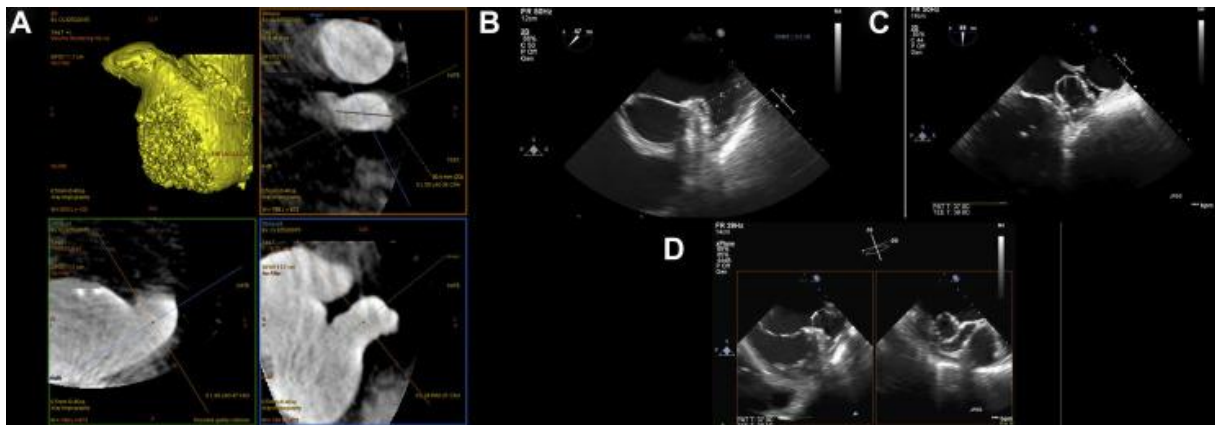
3D rotational angiography and 3D echocardiography images from the single non-implantable patient. There was no stability of the device in the appendage. (A) 3D appendage segmentation. Multiplanar reconstruction at the neck of the appendage. Maximum diameter is 30.5 mm. (B) transesophageal echocardiography at 47° plane. Maximum diameter is 27 mm. (C) the view of device in the left atrial appendage after deployment, showing lack of compression. (D) Biplane view of the deployed device in the appendage, showing lack of stability.
